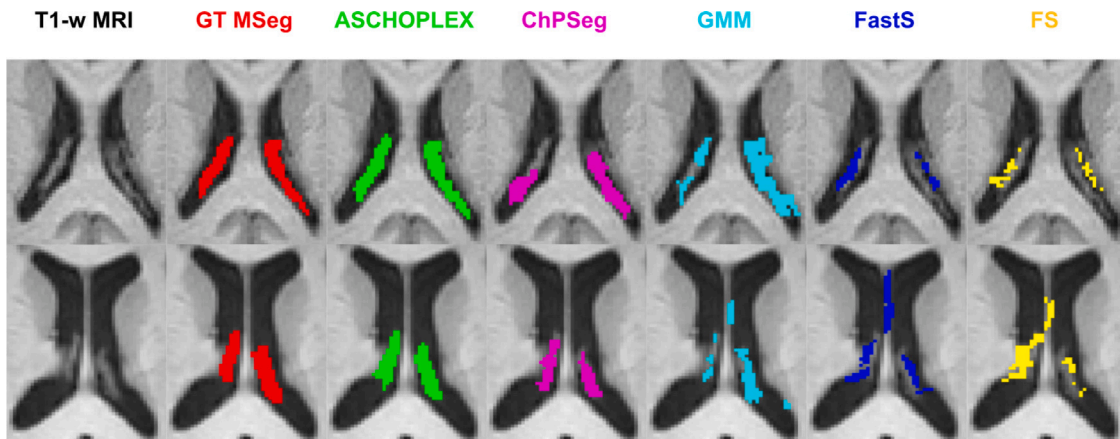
Comparison of Choroid Plexus predicted segmentation. From left to right, the figure shows a zoom-in of the 3D T1-w MRI with superimposed manual segmentation (GT MSeg) in red, proposed method ASCHOPLEX in green, FastSurfer (FastS) in blue, ChPSeg in pink, Gaussian Mixture Model (GMM) in light-blue, and FreeSurfer (FS) in yellow. Percentage Volume Difference metric (reference GT MSeg) for the top subject (best case patient): ASCHOPLEX +0.32%, ChPSeg +5.92%, FS -48.79%, FastS -40.79%, GMM +19.52%; for the bottom subject (worst case patient): ASCHOPLEX -15.37%, ChPSeg -53.94%, FS -68.47%, FastS -62.80%, GMM -40.22%.
